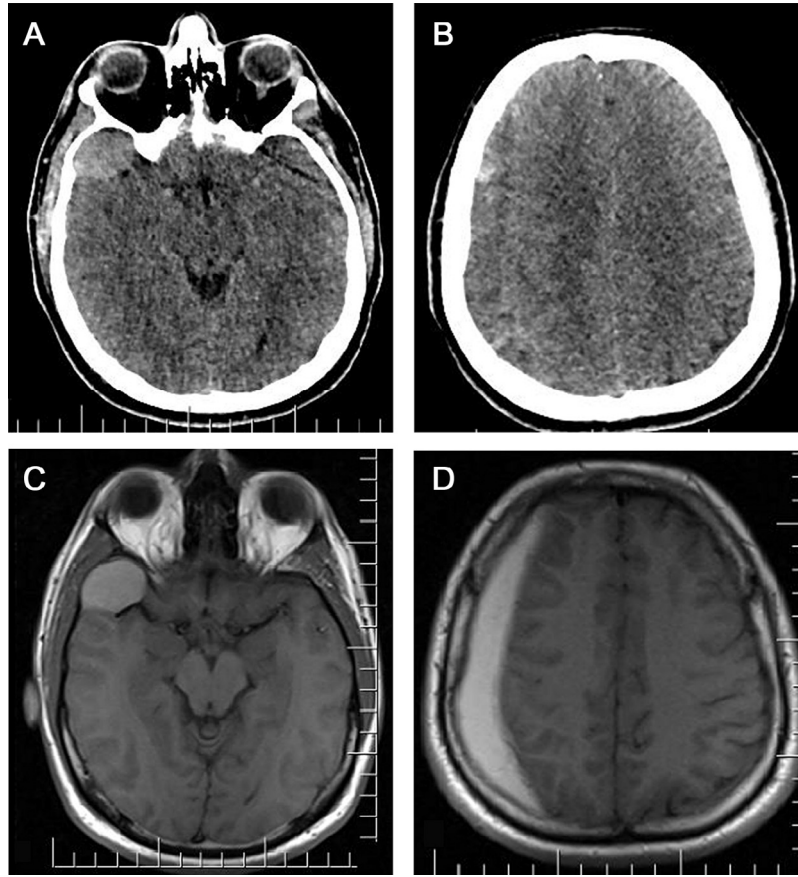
Hyperdense extra-axial cyst in the right anterior middle cranial fossa consistent with a blood-filled arachnoid cyst is seen on initial CT scan at admission (A). A companion right parietal SDH isodense to adjacent brain parenchyma with mild mass effect on the right hemisphere was also evident (B). Both the arachnoid cyst and ipsilateral SDH demonstrate high signal intensity on T1W MRI (C and D). CT, computed tomography; MRI, magnetic resonance imaging; SDH, subdural hematoma.
